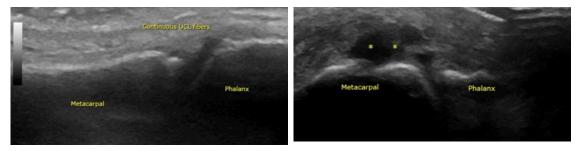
Normal ultrasound of the 1st MCP joint with the UCL visibly intact.
